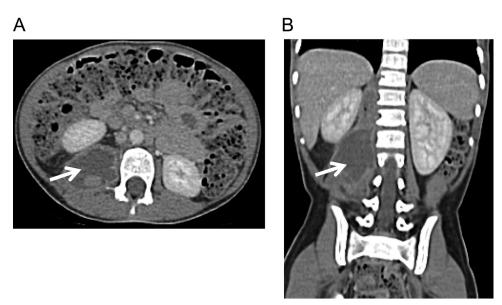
Chest CT revealed a right paraspinal lesion (white arrow) (A), with apparent tethering to thoracolumbar vertebrae evident on coronal section (B).
